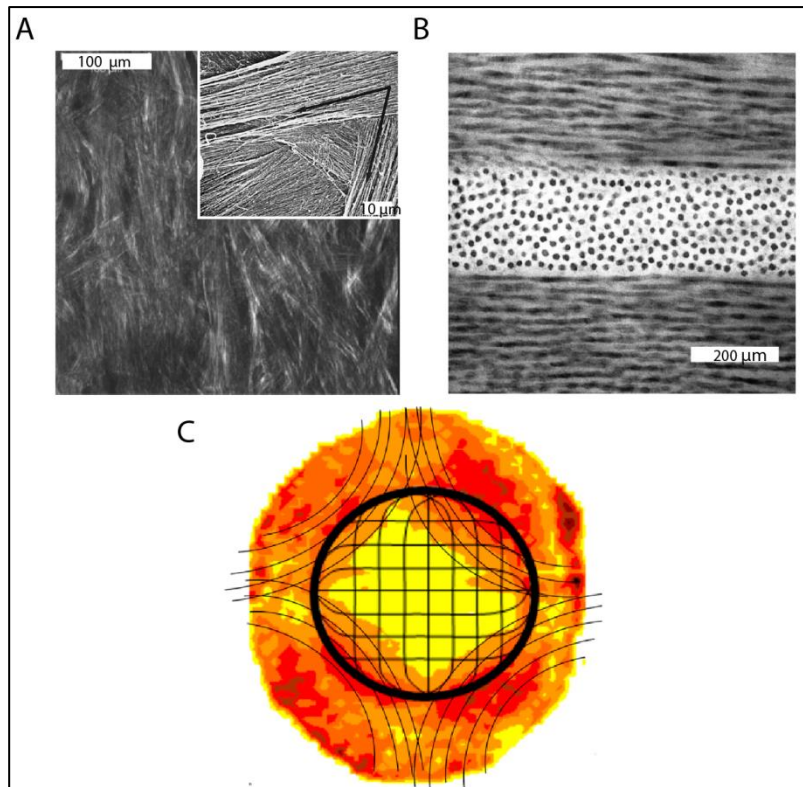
Figures showing orientation of lamellae in the structure of the cornea. A) SEM showing the directions of the adjacent lamellae. (Adapted from Meek and Knupp, 2015. Inset is adapted from Meek and Fullwood, 2004). B) TEM showing orientation of collagen fibrils in adjacent lamellae. Regular diameter and spacing of the fibers are clearly seen in the mid-lamellae (fibers directed out of the page). (Adapted from Fullwood, 2004). C) Simplified model based on X-Ray Data showing fibril orientation in the cornea. (Adapted from Meek and Knupp, 2015). Scale bars are: (A) 100 μm and inset is 10 μm, and (B) 200 nm.
